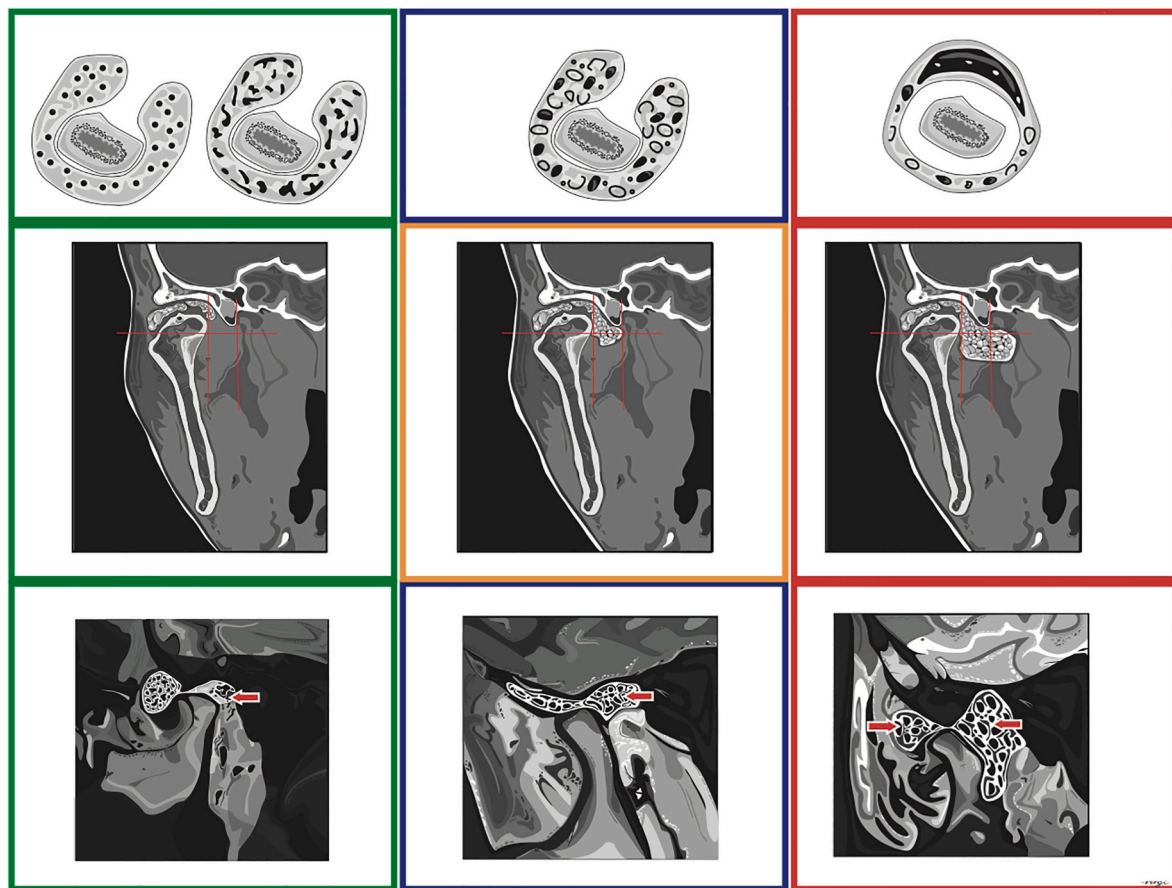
Using color coding, an imaging guide for decision-making based on imaging classification for chondromatosis on MRI.
